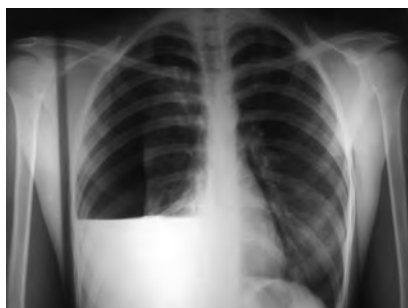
Hemopneumothorax. Posteroanterior chest X-ray.
